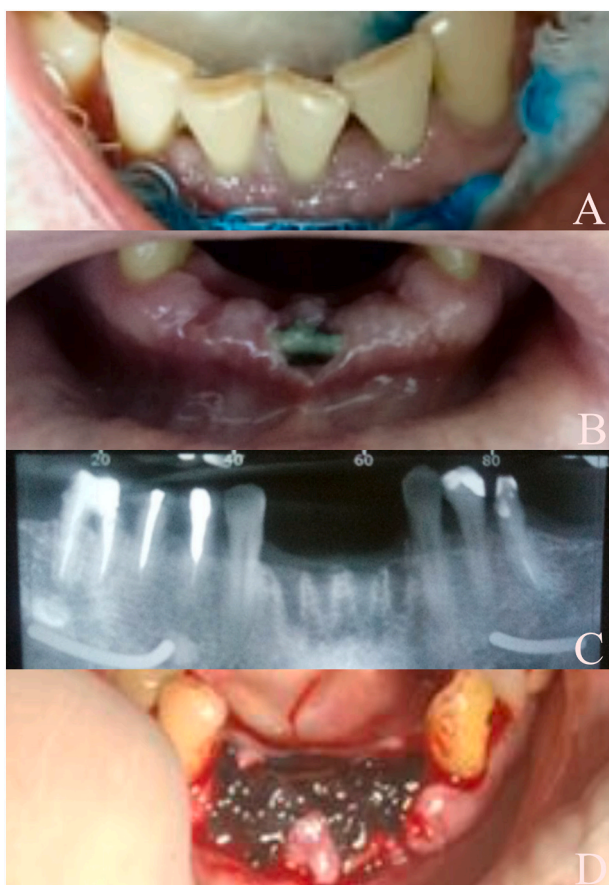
a) periodontal infection in the region of the lower incisors. b) necrosis and purulent secretion. c) jaw radiography. d) necrosis and purulent secretion.
